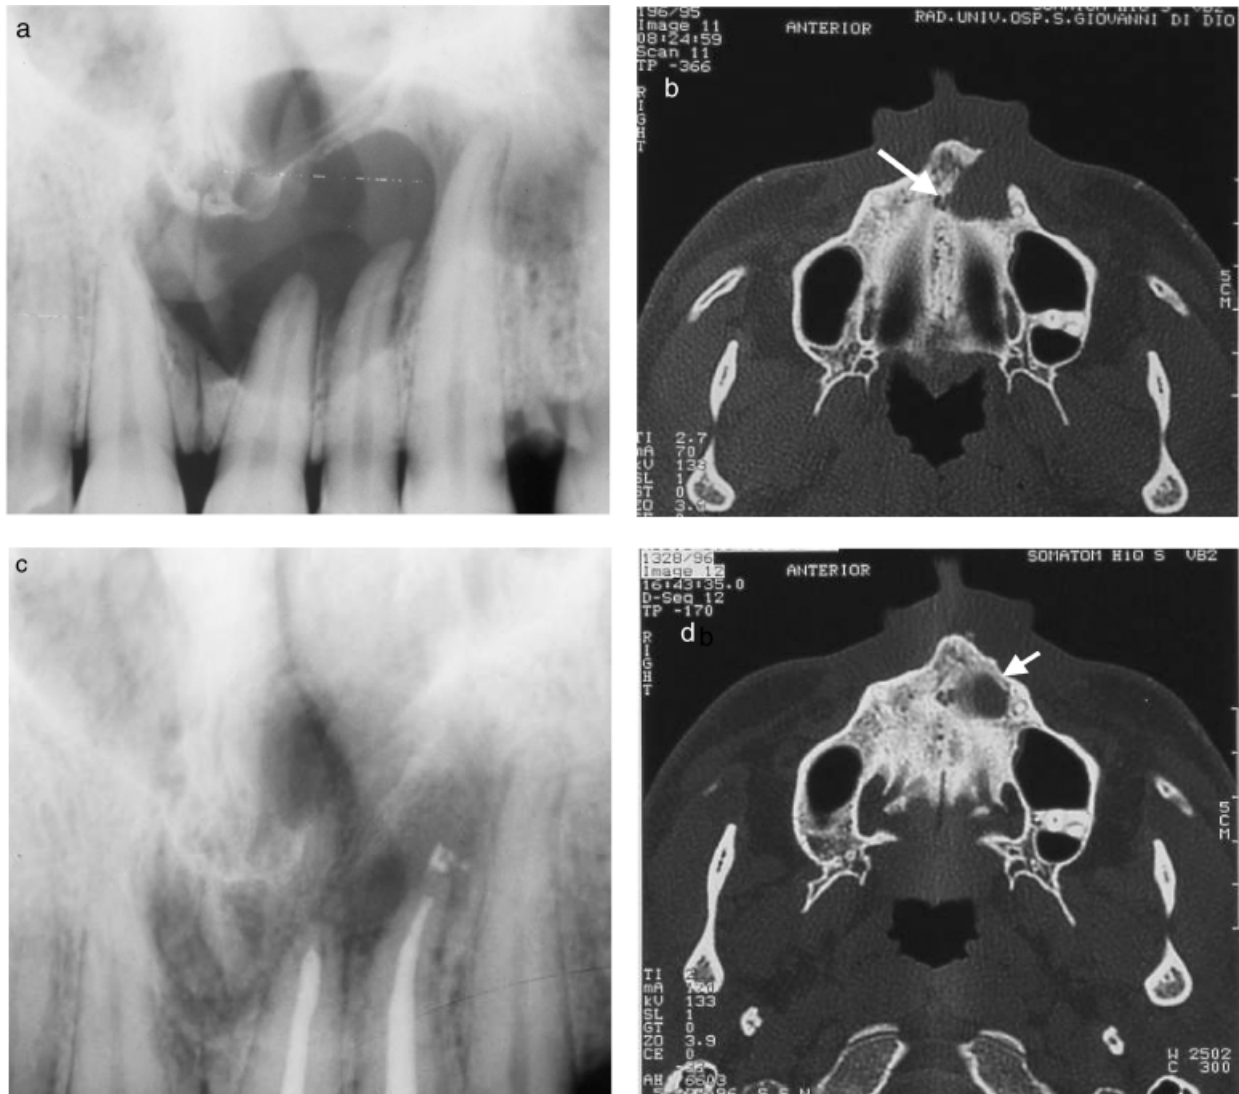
Lesion of endodontic origin in the periapical areas of the upper left front teeth. (a) Periradicular lesion as seen in the panoramic radiograph. (b) The same lesion as seen in the axial slice of the computerized tomography (CT). The major diameters of the lesion and the erosion of the external cortical plate and the involvement of the incisal canal (arrow) are shown. (c) Healing of the same lesion as seen in the panoramic radiograph 18 months after endodontic treatment. Healing appears close to be completed. (d) CT axial slice of the lesion at the 18 months follow-up. The CT shows that the external cortical plate has been repaired (arrow), but the lesion in the bone is still large.
